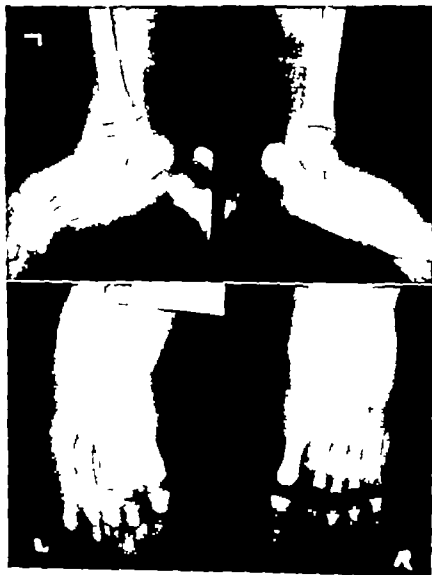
L. G. Lateral and anteroposterior roentgenograms of bilateral critical talus in a baby. The calcaneus is tilted downward, and the sole is convex. The talus is directed inward, particularly in the right foot.
